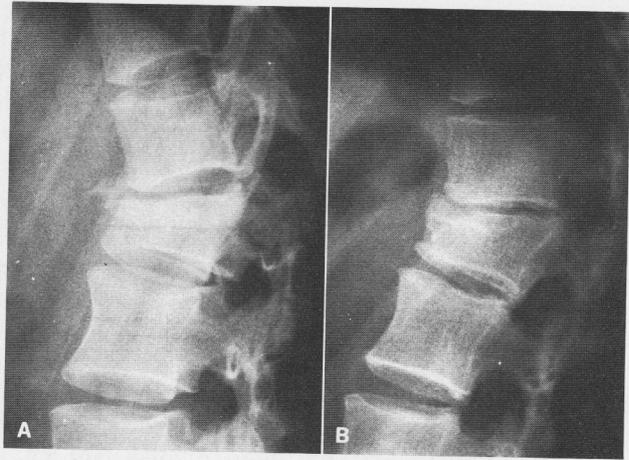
(A) Female aged 61 with a burst fracture of T<sub>11</sub>. There is 20° kyphosis and more than 30% compression. (B) The post reduction radiograph in the hyperextension cast shows good reduction of the deformity. (C) The 10 year follow-up radiograph also shows good correction, with 5° kyphosis, a vertebral height reduction of 30% but with grade 3 spondylotic changes. The patient had mild pain interfering with work and wore a corset at all times.
